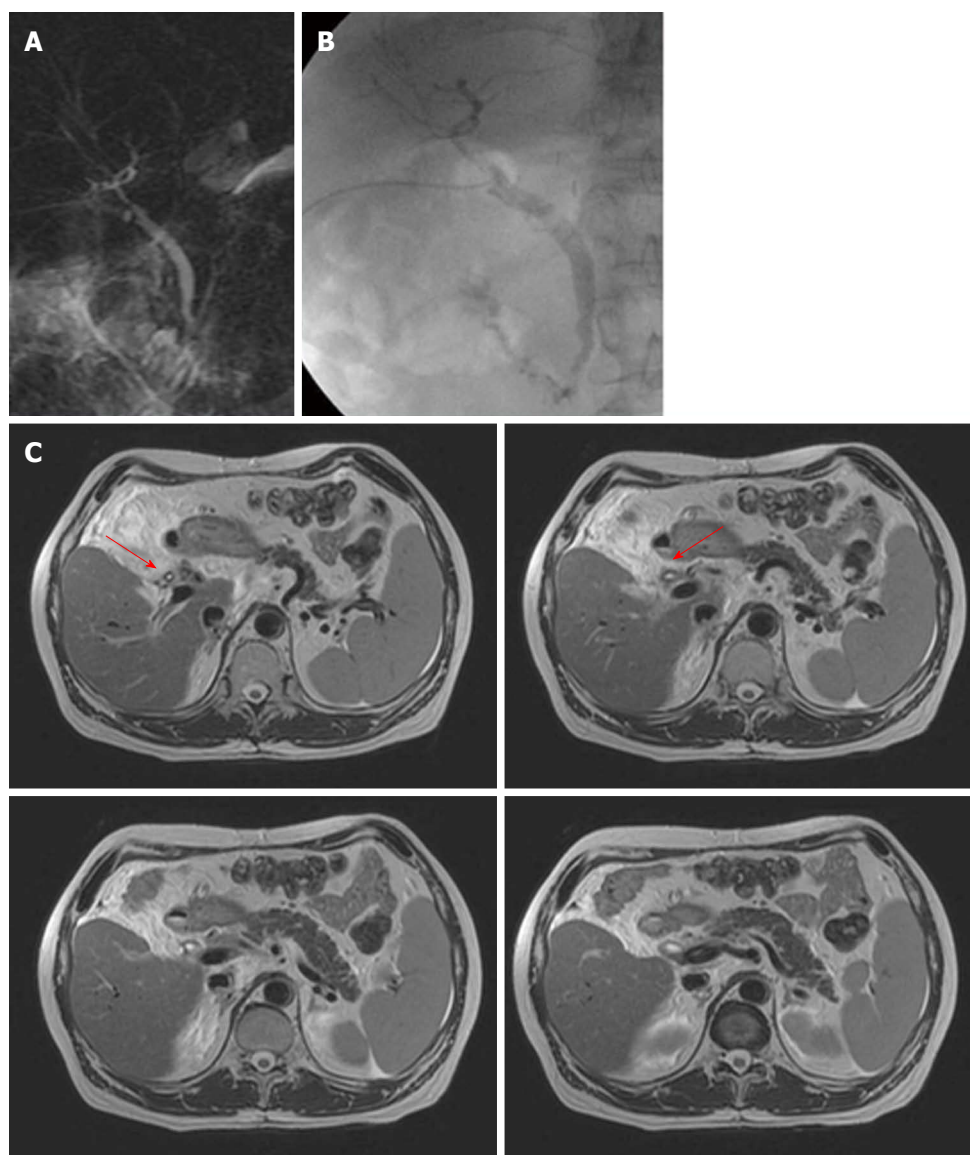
Non-anastomotic biliary stricture: Early ischemic type biliary lesion. A: Single-shot thick-slab magnetic resonance cholangiogram demonstrates discrepancy of caliber between donor and recipient extrahepatic biliary tract without dilation of intrahepatic biliary system; B: T-tube cholangiography confirms the presence of the mild stenosis; C: Axial T2-weighted images well exhibit the presence of circumferential wall thickening of the extrahepatic biliary tree of the graft (red arrows).
